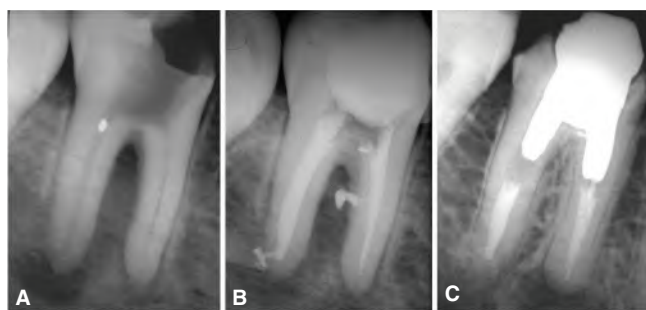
Treatment of a periradicular pathosis in a mandibular first molar of a 28-year-old male considered a failure. A. Preoperative radiograph showing periradicular radiolucencies associated with the mesial and distal roots as well as the furcation area. Root canal space exposed to the oral cavity. B. Immediate postoperative radiograph. Remnants of sealer extruding through a lateral portal of exit toward the furcation area. C. Five-year follow up radiograph showing marked reduction in size of the radiolucency associated with the furcation and the distal root. However, the periapical radiolucency in the mesial root has not been resolved.
